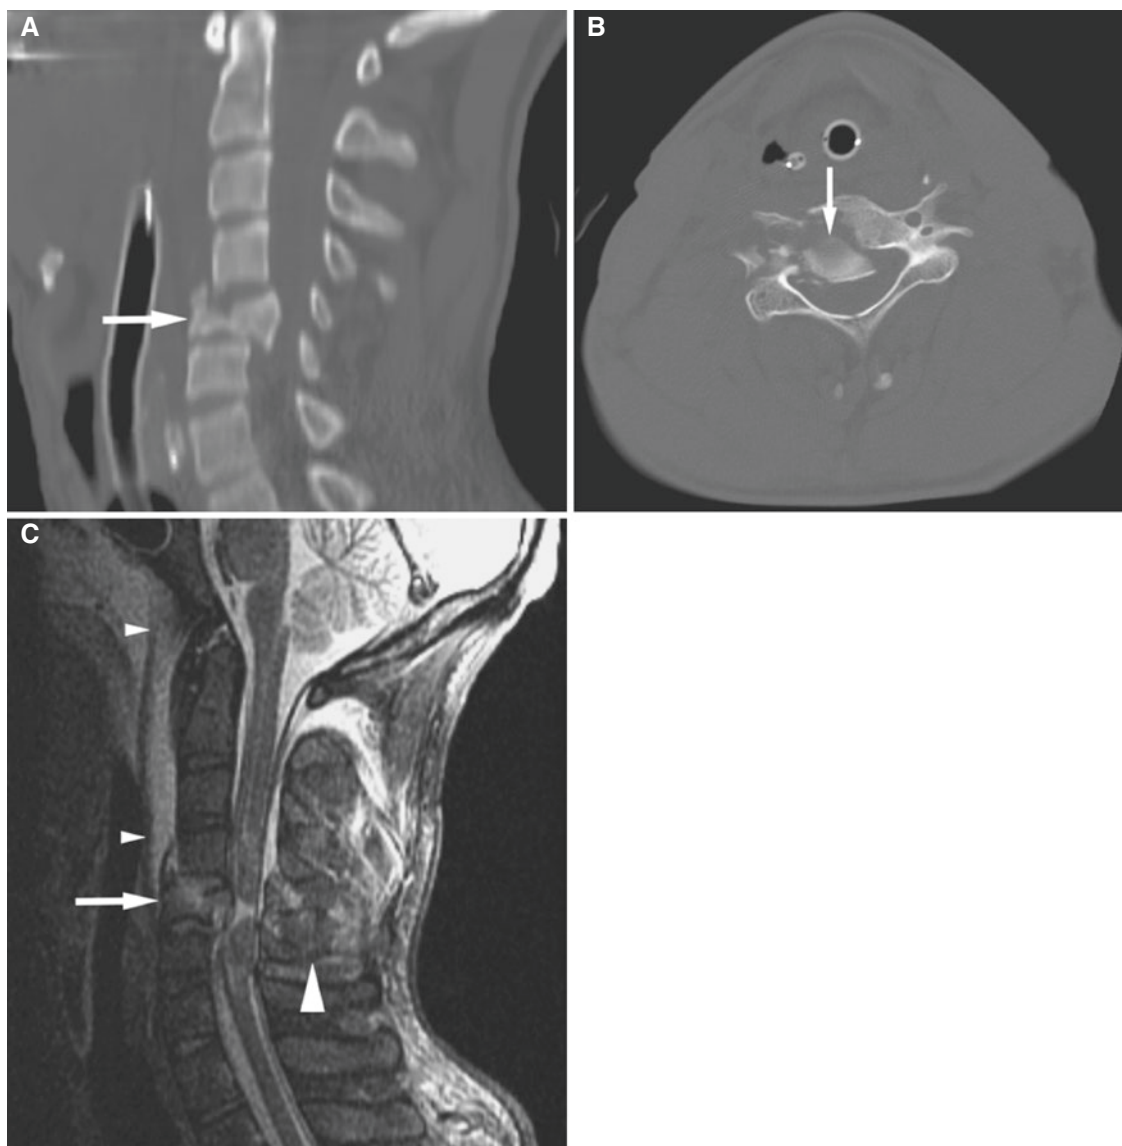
C5 burst fracture; 27-year-old male all-terrain vehicle accident. (A) Sagittally reformatted CT image shows burst fracture of C5 with subluxation and severe central canal narrowing (*arrow*). (B) Axial CT image demonstrates fragment displaced into central canal (*arrow*). Also fracture through right foramen transversarium where vertebral
